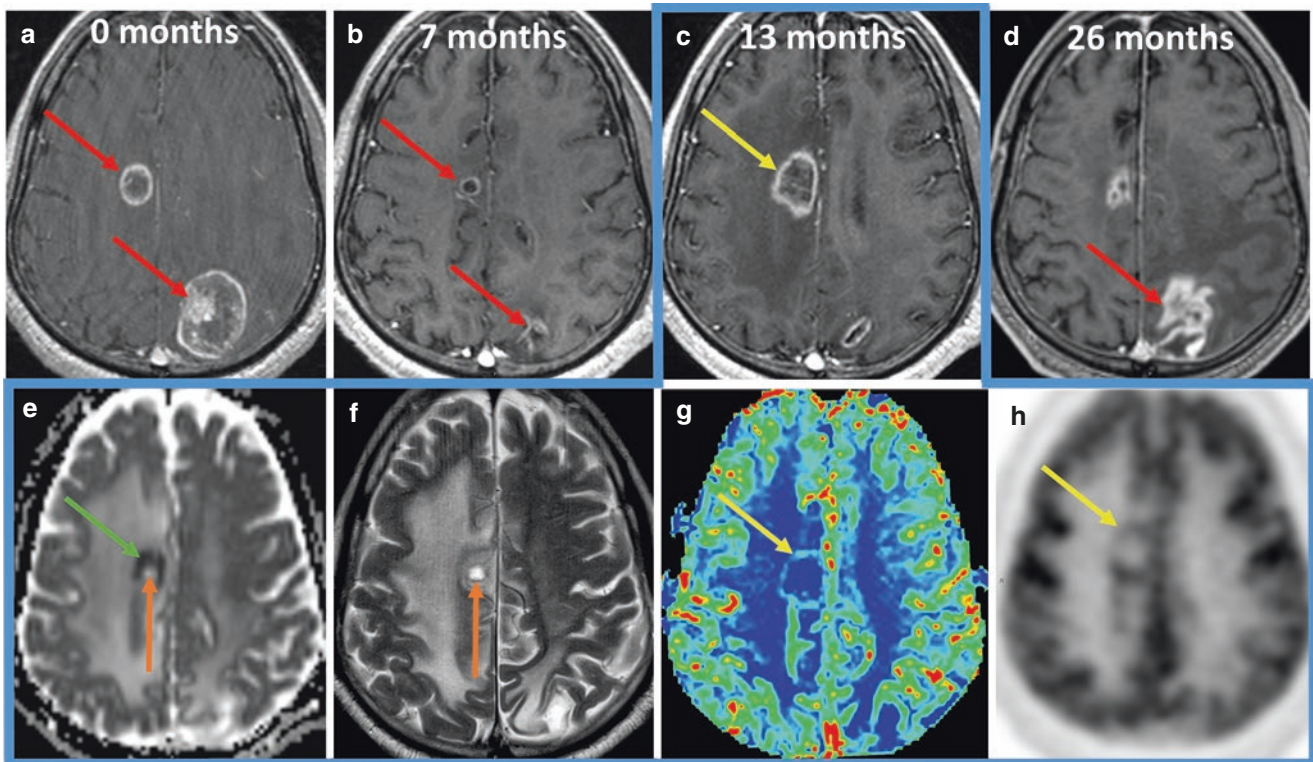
Cerebral metastasis. Pseudoprogression. Axial post-contrast T1-weighted MR images obtained at baseline pretreatment 0 months (a), 7 months (b), 13 months (c), and 26 months (d). Additional images obtained at 13 months (blue border inlay) include axial ADC map MRI (e), axial T2-weighted MRI, axial DSC perfusion-weighted MRI corrected cerebral blood volume map (g), and axial FDG PET attenuation corrected source images (h). Baseline pretreatment exam (a) demonstrates parasagittal right frontal and left parietal non-small cell lung cancer metastasis (red arrows). At 7 months following radiosurgery (b) there is marked treatment response with small residual areas of enhancement present (red arrows). At 13 months (c, e–h) pseudoprogression of the right frontal metastasis is noted as an enlarging area of predominantly peripheral ring-like enhancement (yellow arrow in c).
